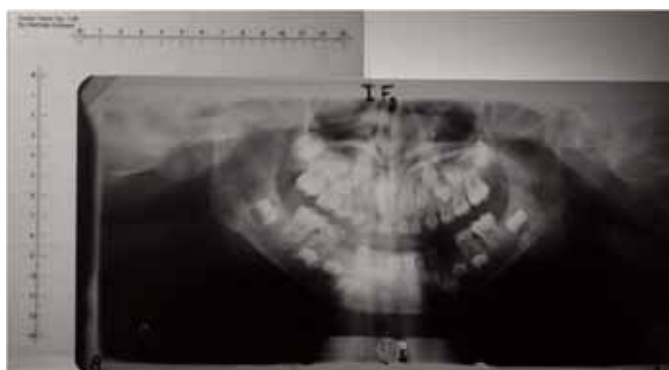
Panoramic X-ray film for an Egyptian girl aged 6 Years
